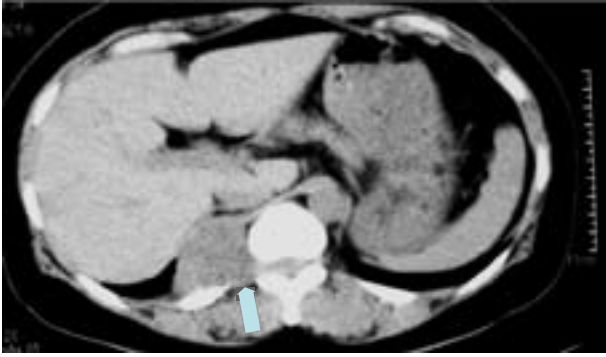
Chest CT shows an approximately 60-mm in diameter dumbbell tumor (arrow) at the 11th thoracic vertebral level.
